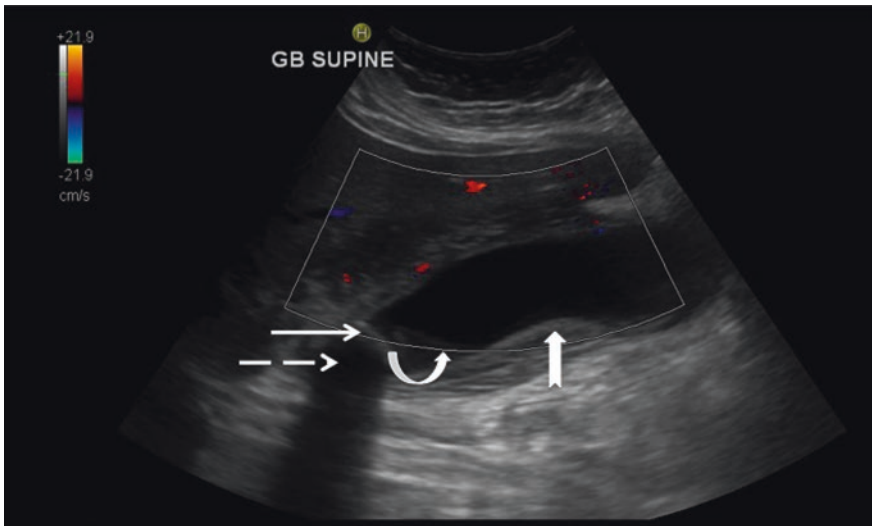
A 54-year-old woman with known gallstones presents with right upper quadrant pain, tenderness and raised inflammatory markers. Ultrasound demonstrates a distended gallbladder full of hypoechoic bile, a hyperechoic calculus (solid arrow) with posterior acoustic shadowing (dashed arrow), sludge (curved arrow) and a thickened gallbladder wall (notched arrow). Findings are in keeping with acute cholecystitis. The patient was sonographically Murphy's positive
